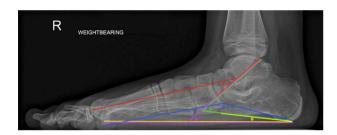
Radiological measurements from a weight-bearing lateral foot radiograph. Lateral talar 1st metatarsal angle: red (A); Calcaneal inclination: yellow (B); Lateral talocalcaneal angle: green (C); Moreau-Costa-Bartani angle: blue (D); Talar declination; pink (E).
